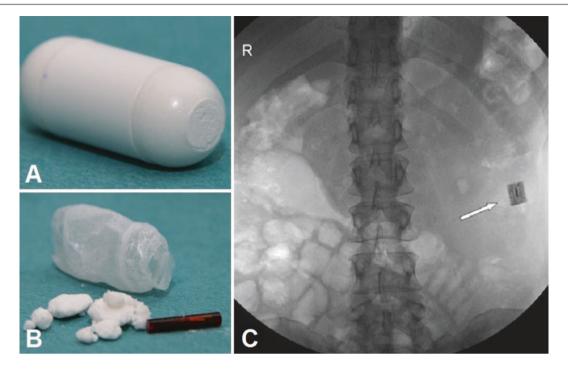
PillCam patency capsule (Medtronic). (a) Intact. (b) Dissolved. (c) Retained on radiograph (Adapted from Costamagna et al. [28] With permission of Springer Nature.)
